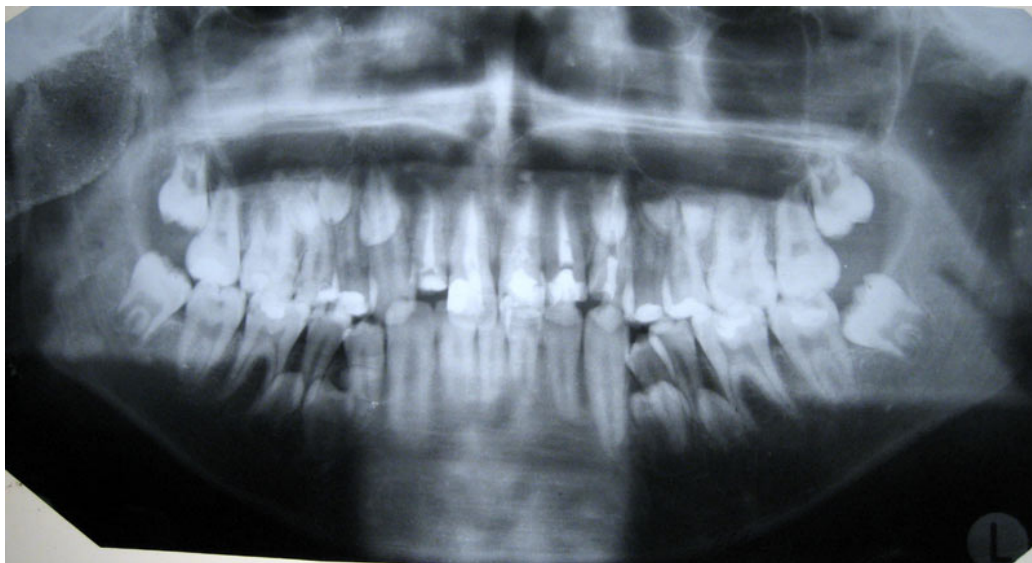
Orthopantomogram showing multiple unerupted teeth.
